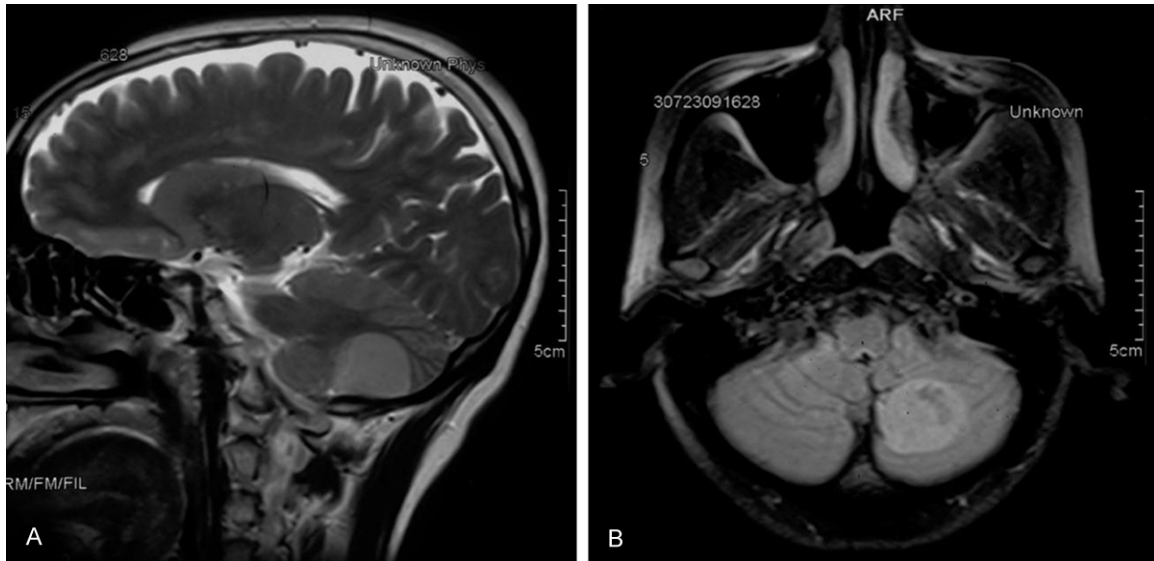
Cranial MRI images: A. T2WI showed that the root of the lesion was attached to the dura mater at the bottom of the posterior fossa. The base of the tumor was wide, and the boundary of the lesion with the cerebellum was clear. B. The axial Flair images showed slight hyper signals within the lesion. The size of the tumor was approximately 2.5 cm, the edge was clear.
